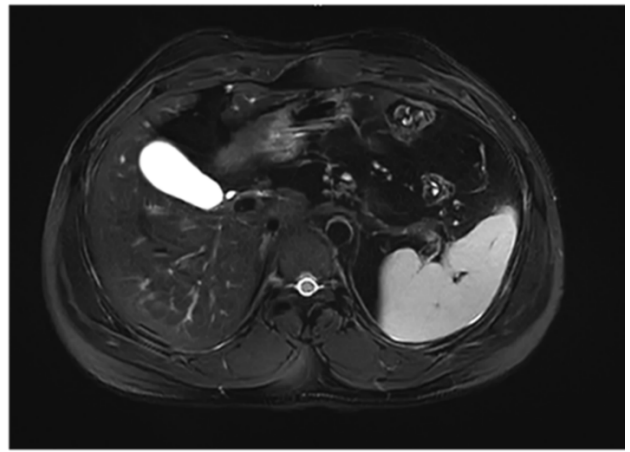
Liver MRI slice for all sequences of a representative subject.
